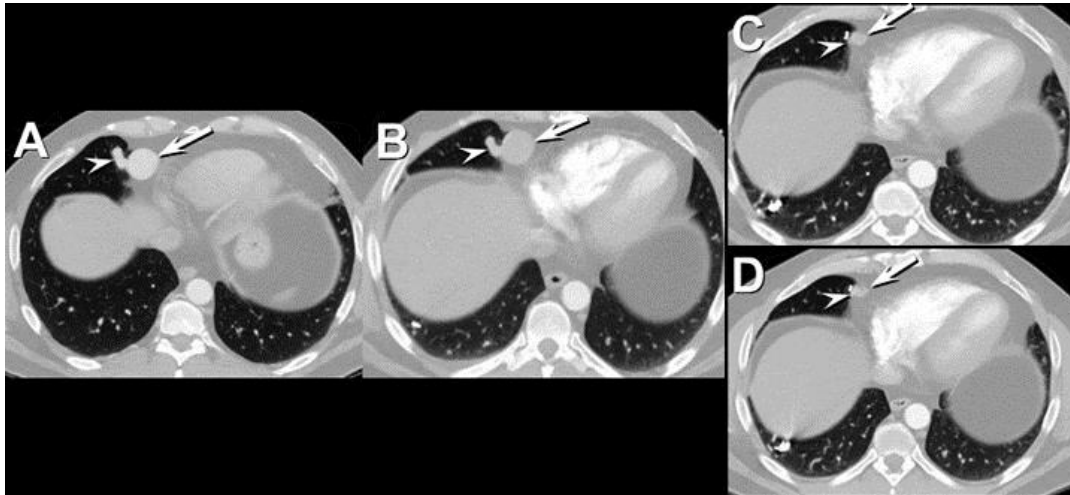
Axial enhanced thoracic CT performed using a CT pulmonary angiography protocol at presentation (A), 2 months following coil embolization of the two largest arteriovenous malformations (B), and 10 months following coil embolization of the two largest arteriovenous malformations (C and D) shows that the initially intensely enhancing vascular nidus (arrow in A) displays diminished enhancement 2 months after treatment (arrow in B) and no longer enhances and is markedly decreased in size 10 months following endovascular therapy (arrows in C and D). The large feeding artery is visible prior to therapy (arrowhead in A), shows somewhat diminished enhancement 2 months following endovascular therapy (arrowhead in B), and significantly involutes 10 months following endovascular therapy (arrowheads in C and D). The coils used to treat the smaller right lower lobe arteriovenous malformation are visible in B-D.
